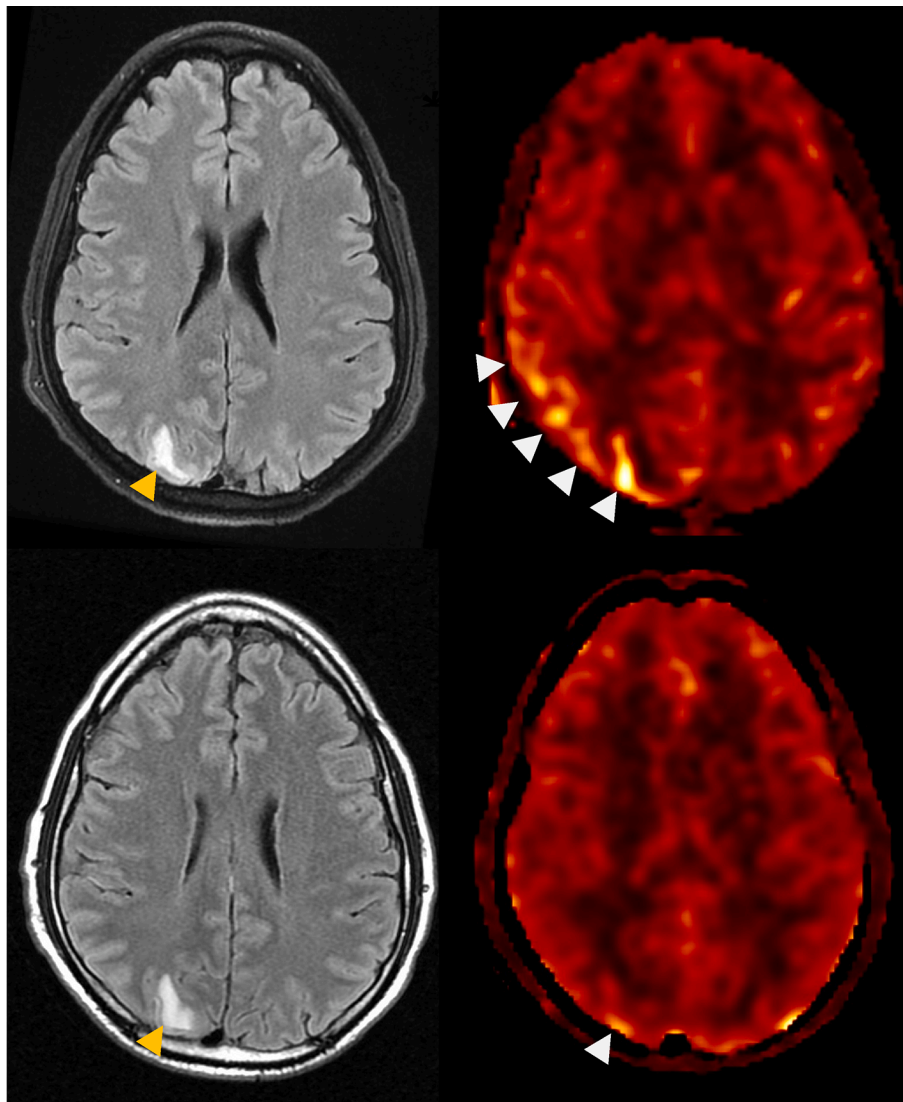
Axial T2 FLAIR (left) and ASL color (right) perfusion maps on day 1 (top row) and day 3 (bottom row) of a 33-year-old male with methamphetamine-induced PRES. Hyperperfusion (white arrowheads) was near-completely resolved three days after the initial presentation while FLAIR hyperintensity (orange arrowheads) persisted. (For interpretation of the references to color in this figure legend, the reader is referred to the web version of this article.)
